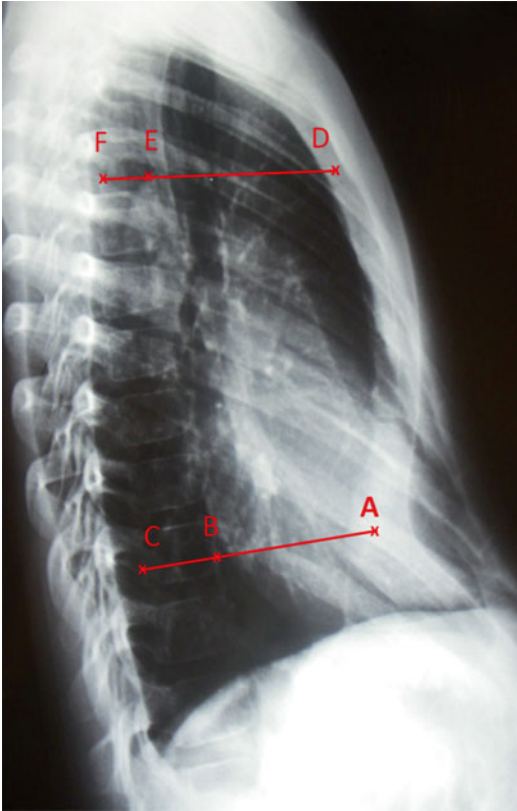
Lateral Chest-X-Ray of a PE patient. Note Rebeis et al. and Derveaux et al. measurements to calculate the Lower Vertebral Index at the xiphisternal junction. BC =sagittal diameter of the vertebral body and AC =sagittal anteroposterior diameter of the back side of the sternum to the back side of the vertebral body. Derveaux et al. also measure the Upper Vertebral Index at the sternomanubrial junction. EF =sagittal diameter of the vertebral body and DE =sagittal anteroposterior diameter of the back side of the sternum to the back side of the vertebral body. The Configuration Index is the ratio between the sagittal anteroposterior diameter of the back side of the sternum to the front side of the vertebral body at the xiphisternal (DE) and sternomanubrial (AB) junctions
